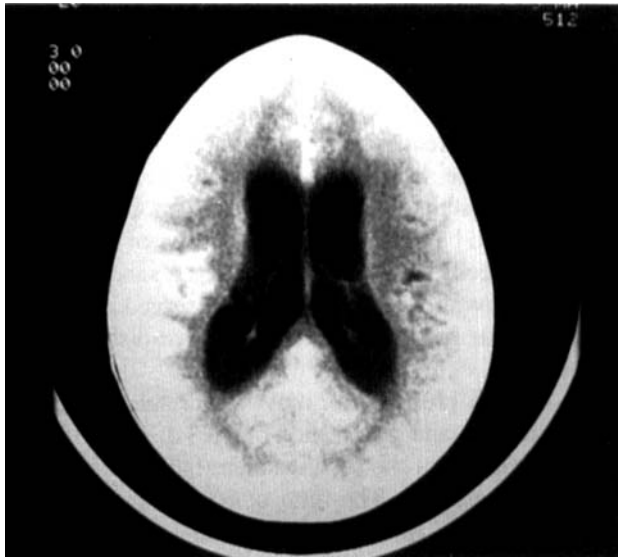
Case 3. CT scan shows multiple areas of bright contrast enhancing tumor.
